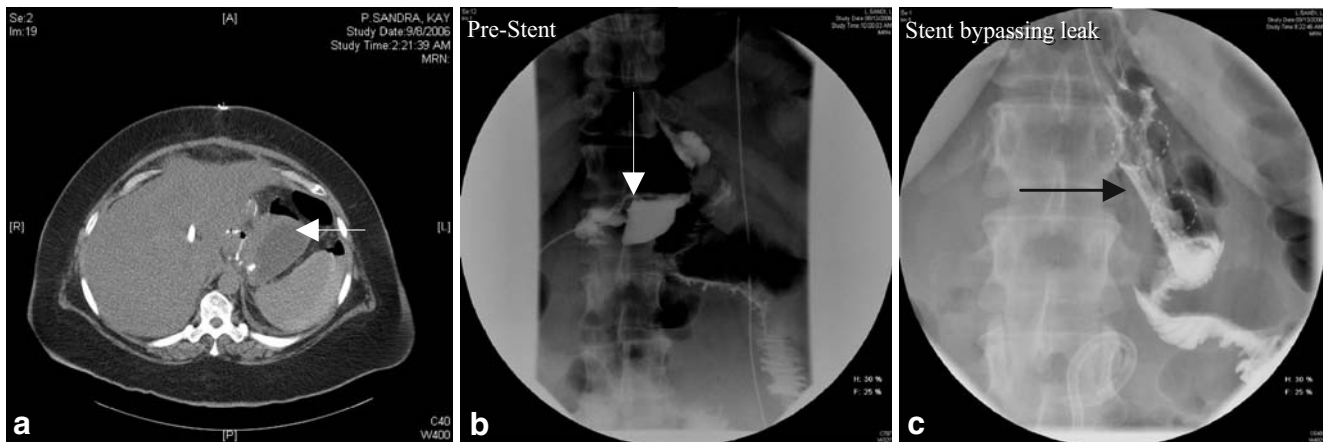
a, b, c CT showing abscess after gastrojejunal anastomosis (a) with leak on contrast study (b) and sealing after stent placement (c).
